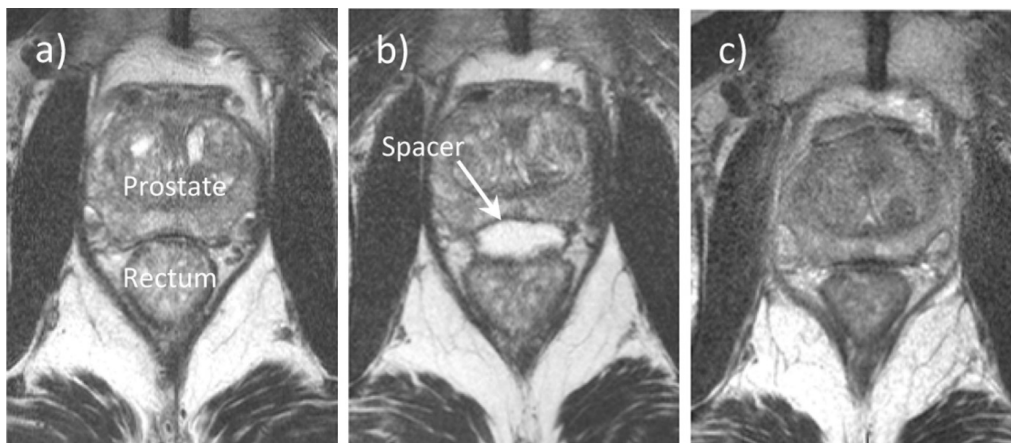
T2-weighted magnetic resonance images of a spacer patient at baseline (a), post-application (b), and 12 months after spacer application (c). Printed with permission (205)
